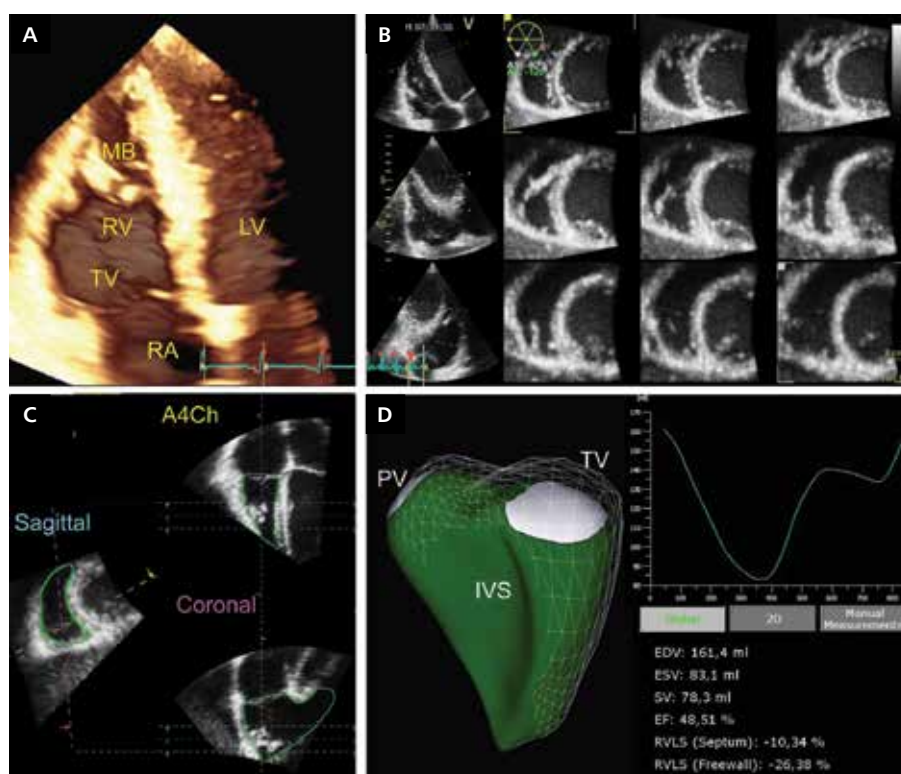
Display modes of a three-dimensional (3D) data set of the right ventricle (RV) obtained from the RV-focused apical four-chamber view using full-volume multi-beat acquisition (four to six consecutive beats) with adjusted depth and volume width to encompass the entire RV; A. Volume rendering demonstrating the RV anatomy; B. Multi (twelve)-slice mode including three longitudinal (0° , 60° , and 120°) and nine transversal equidistant tomographic views between the apex and the base of the RV, mainly used for regional wall motion and RV shape analysis; C. Semiautomatic identification of the RV endocardial surface in the RV short-axis, four-chamber, and coronal views; D. Surface rendered 3D model of the RV (green model) combining the wire-frame (white cage) display of the end-diastolic volume. Surface-rendered dynamic model changes its size and shape throughout the cardiac cycle enabling the visual assessment of the RV dynamics and quantitation of RV volumes and ejection fraction; EDV — end-diastolic volume; EF — ejection fraction; ESV — end-systolic volume; IVS — interventricular septum; LV — left ventricle; MB — moderator band; PV — pulmonic valve; RA — right atrium; RVLS — right ventricular longitudinal strain; SV — stroke volume; TV — tricuspid valve
